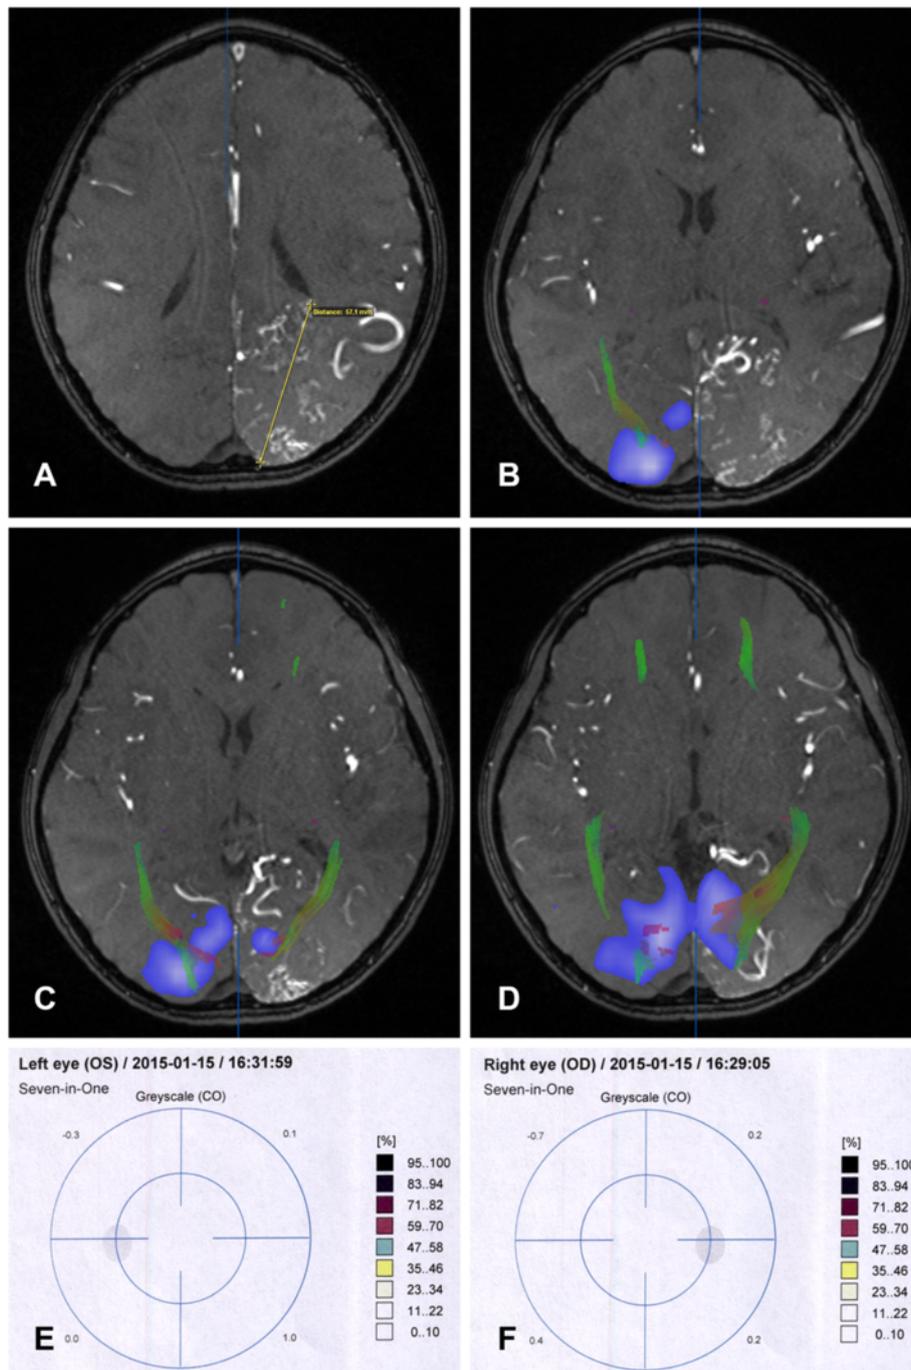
Case 42. A 10-year-old male without a history of hemorrhage. a Enhanced structural axial T1-weighted image showing a left occipital diffuse AVM with a maximum diameter of 57.1 mm (yellow line). b–d Based on enhanced structural axial T1-weighted image, fiber tracking showing the asymmetry of optic radiation (green), and visual cortex (blue). Both the AVM-OR and AVM-VC distances were zero. e–f Visual fields testing showing normal visual fields
